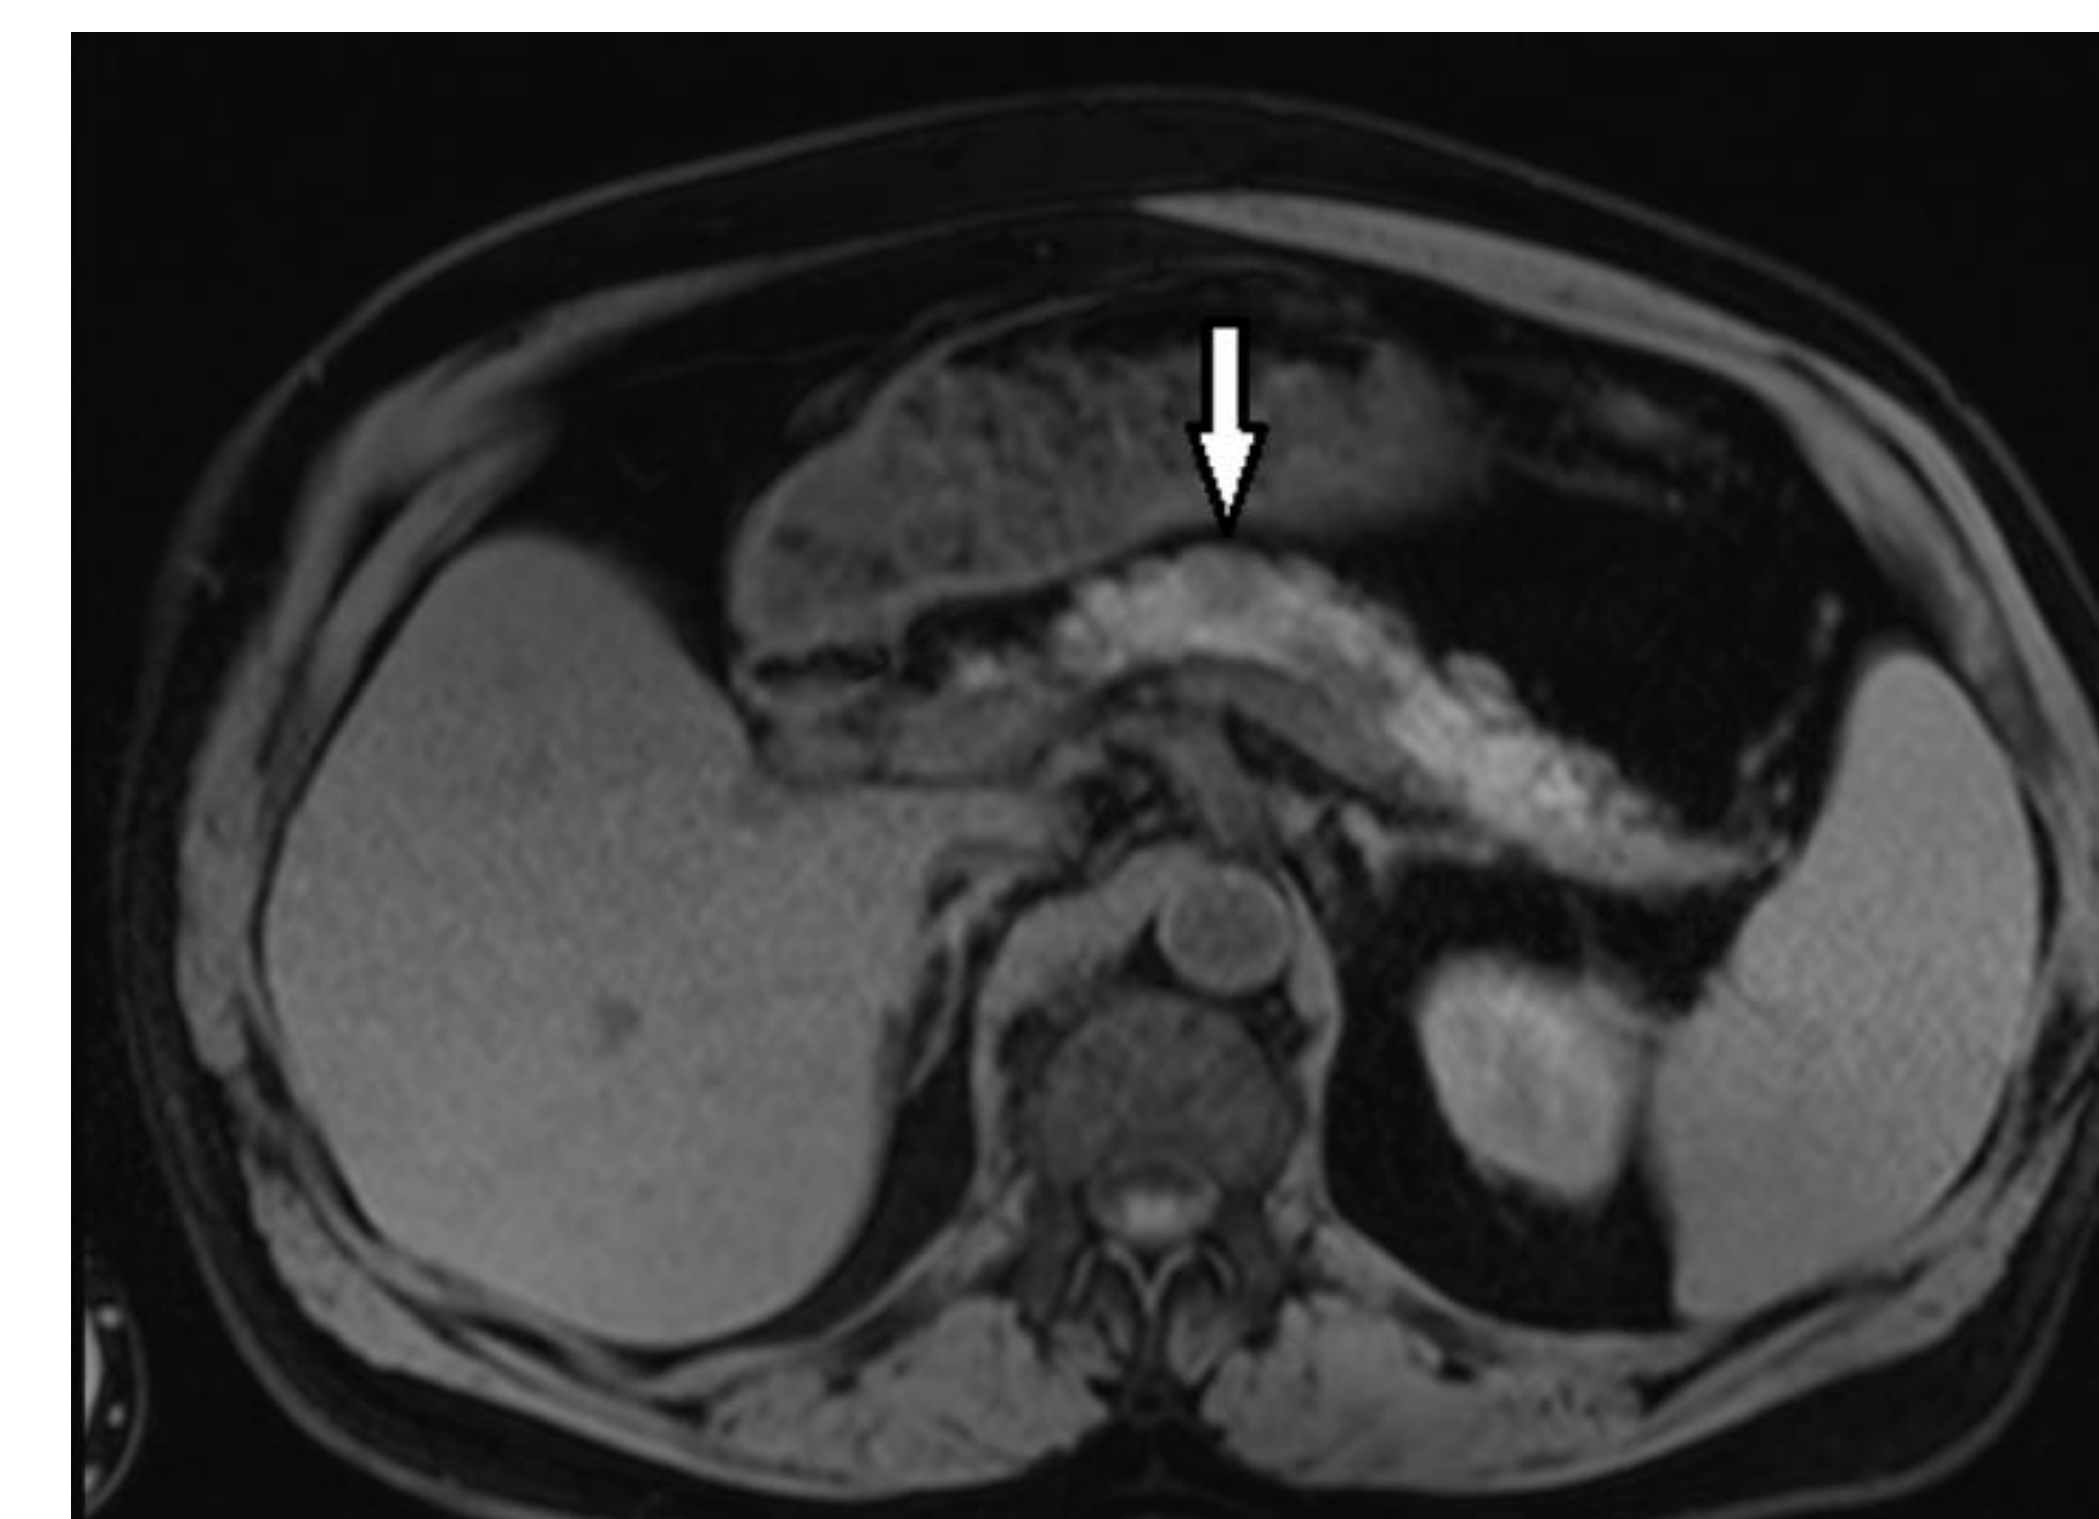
Axial abdominal MRI. T1 fat saturation-normal pancreatic tissue surrounding tumor (arrow) is hyperintense
